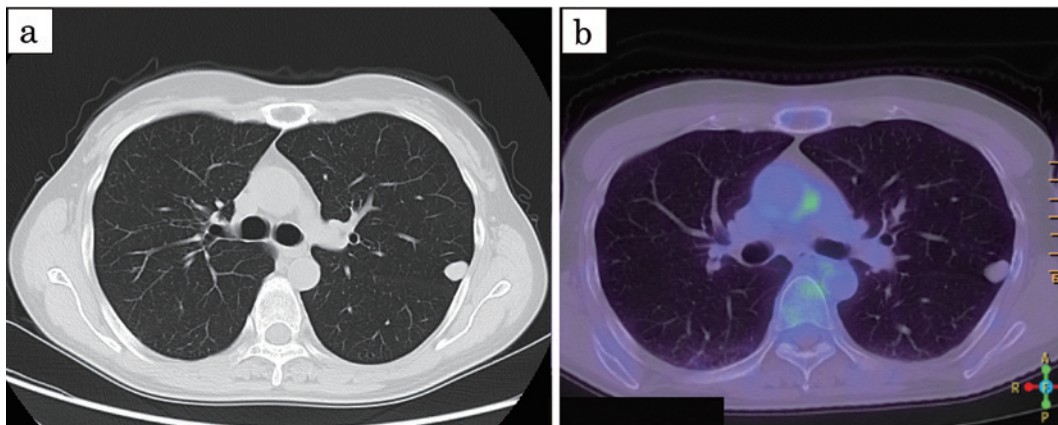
Chest CT scan showing a well-circumscribed nodule in the upper lobe of the left lung (a). FDG-PET revealed no uptake in the lesion (b).
